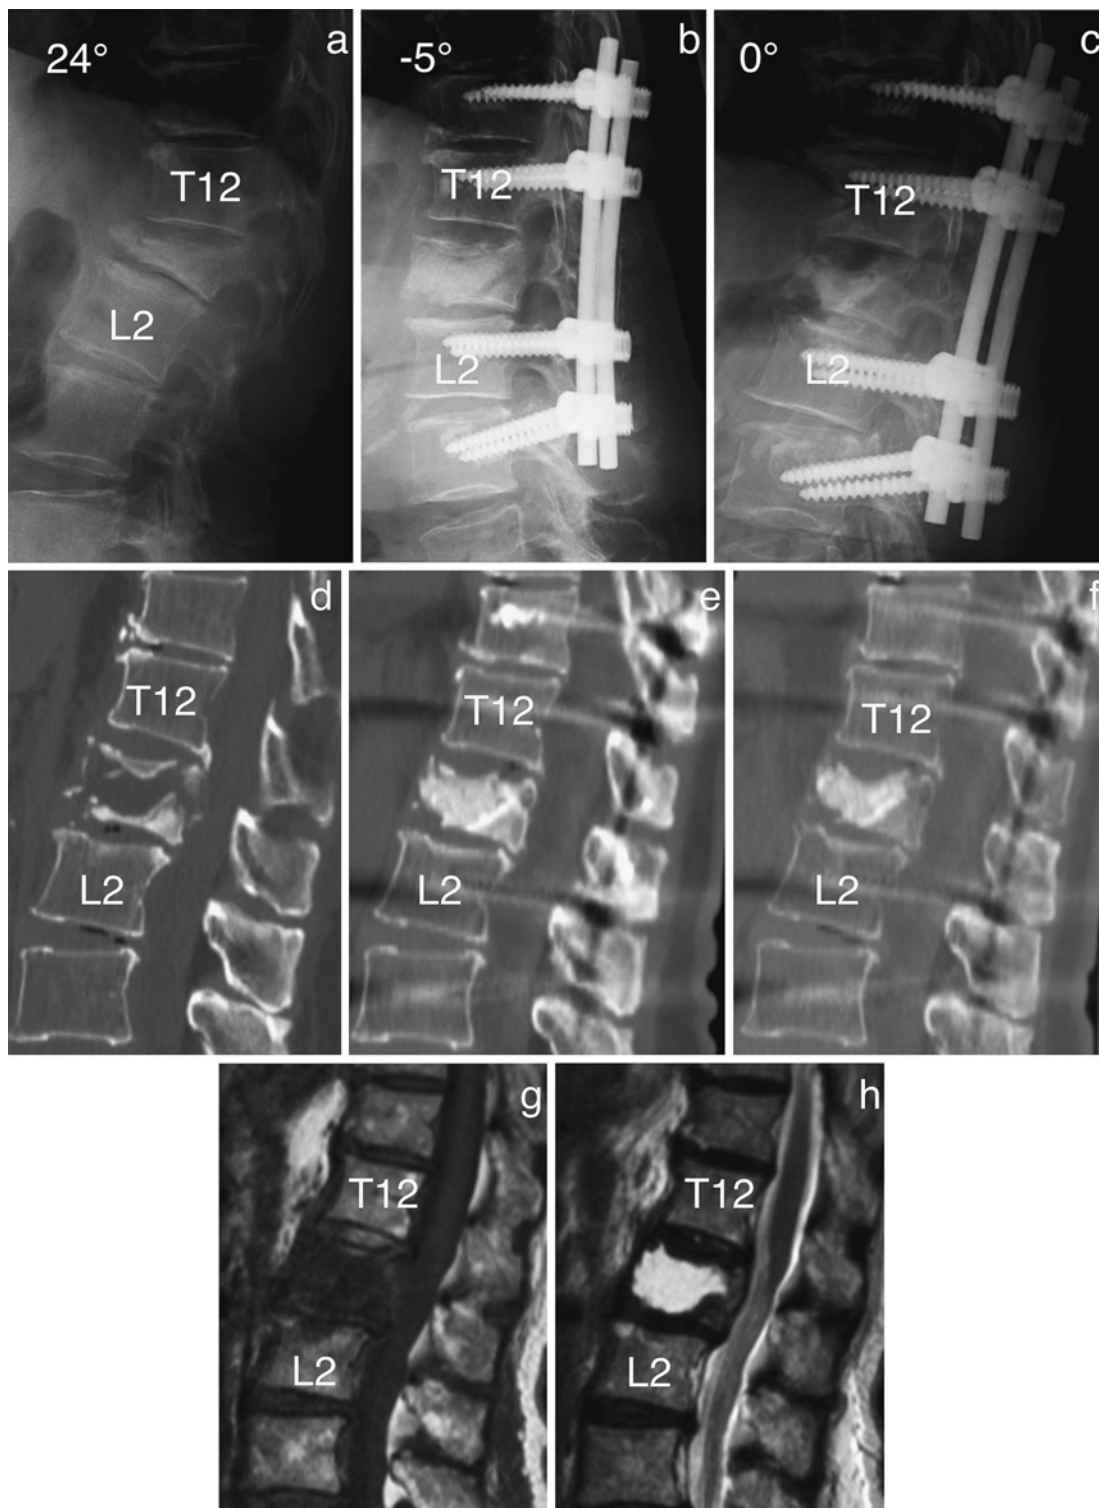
Patient 3. Lateral plain radiographs and computed tomography images obtained before surgery (a, d), immediately after surgery (b, e), and at the last follow-up (c, f). Magnetic resonance images obtained before surgery showed that the retropulsed bone fragments compressed the spinal cord (g, h).
